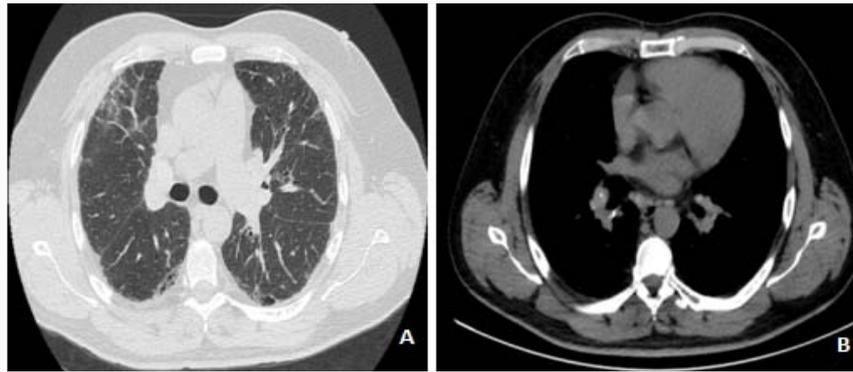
A) HRCT with GGOs, subpleural reticulation and traction bronchiectasis with upper lobe predominance; B) mediastinal lymph nodes with “eggshell” calcification.
